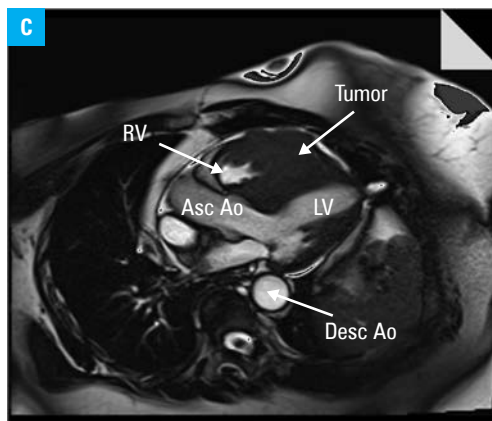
C – dynamic gadolinium perfusion study showing a large tumor almost completely obstructing the RVOT with no first-pass enhancement; D – magnetic resonance imaging (short-axis view) showing the tumor infiltrating the myocardium and epicardium. A delayed enhancement technique revealed areas of heterogeneous enhancement due to regional variations in vascularity and distribution volumes (ie, areas of necrosis) within the tumor.
